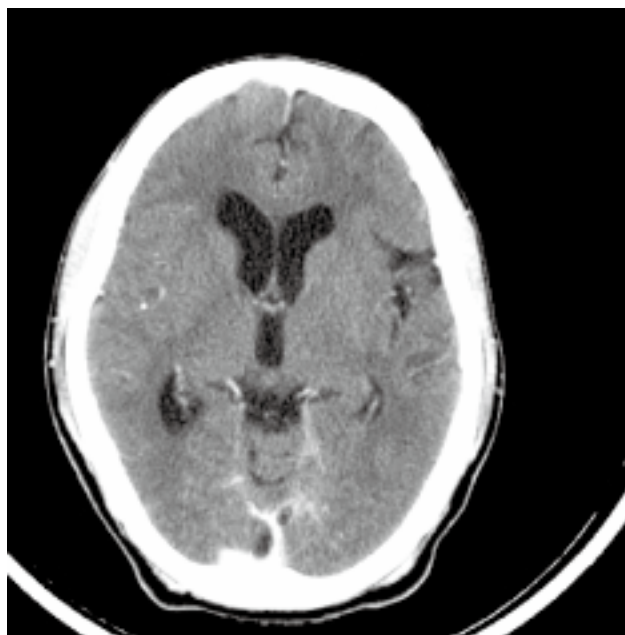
Computed tomography of brain. It shows meningeal enhancement and mild hydrocephalus.
